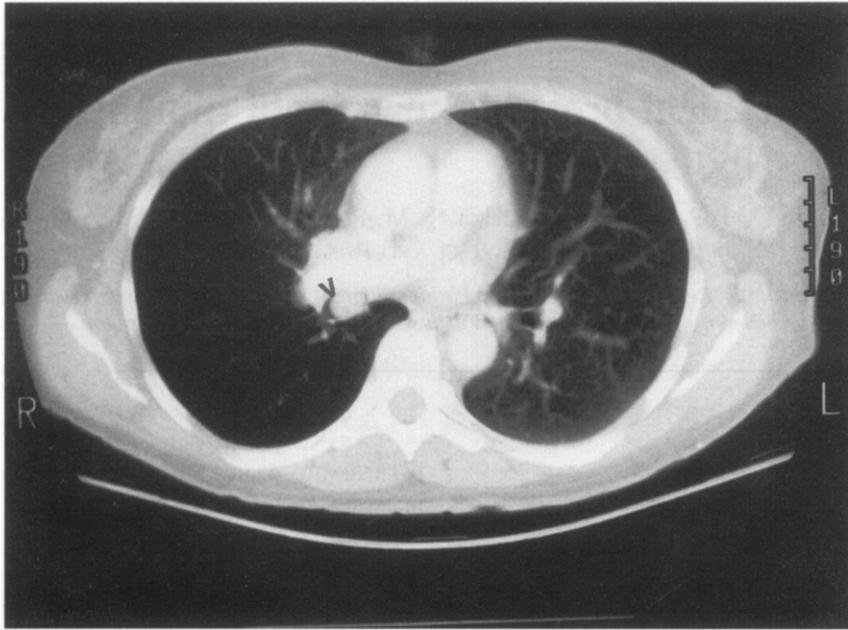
Chest CT scan, showing a tumour in the intermediate bronchus (arrow), hilar lymphadenopathy and air trapping (case 1).
